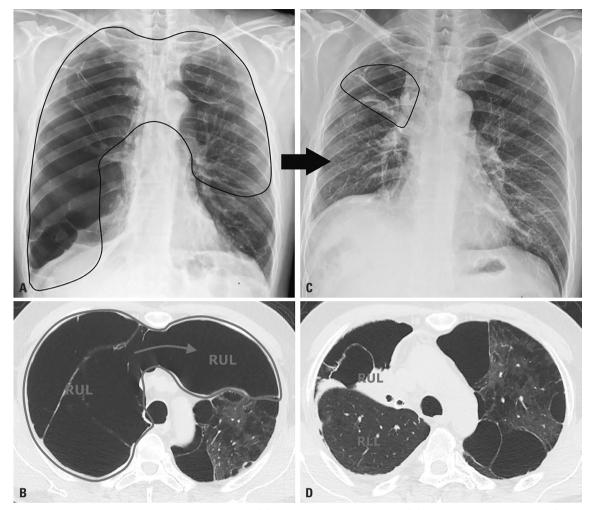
Changes in radiologic findings before and after treatment. (A) Chest X-ray before treatment. (B) Chest computed tomography (CT) scan before treatment. (C) Chest X-ray and (D) chest CT scan after treatment. Chest X-ray in the posteroanterior projection and CT scan show an extensively hyperaerated RUL that is entirely replaced by multiple clustered giant bullae. Owing to the mass effect of the over-expanded RUL, the adjacent right middle and lower lobe were severely compressed within the right hemithorax. Moreover, the super-overinflated RUL encroaches upon even the contralateral left hemithorax across the anterior mediastinal junction line, occupying a large space in the left hemithorax, which was also detrimental to otherwise normal inflation of the left lung. After insertion of endobronchial valves and percutaneous drainage catheter, the volume of previously overinflated RUL markedly decreased, showing near-complete lobar atelectasis. RUL, right upper lobe; RLL, right lower lobe.
